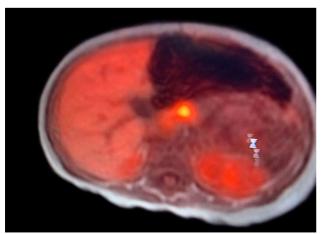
Focal lesion located in the body-tail of the pancreas with ¹⁸F-DOPA PET/CT.
